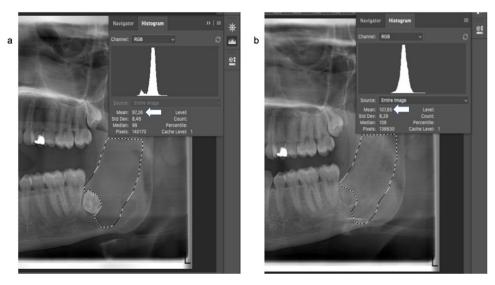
Comparison of preoperative (a) and postoperative (b) mean grayscale values on panoramic radiographs.
